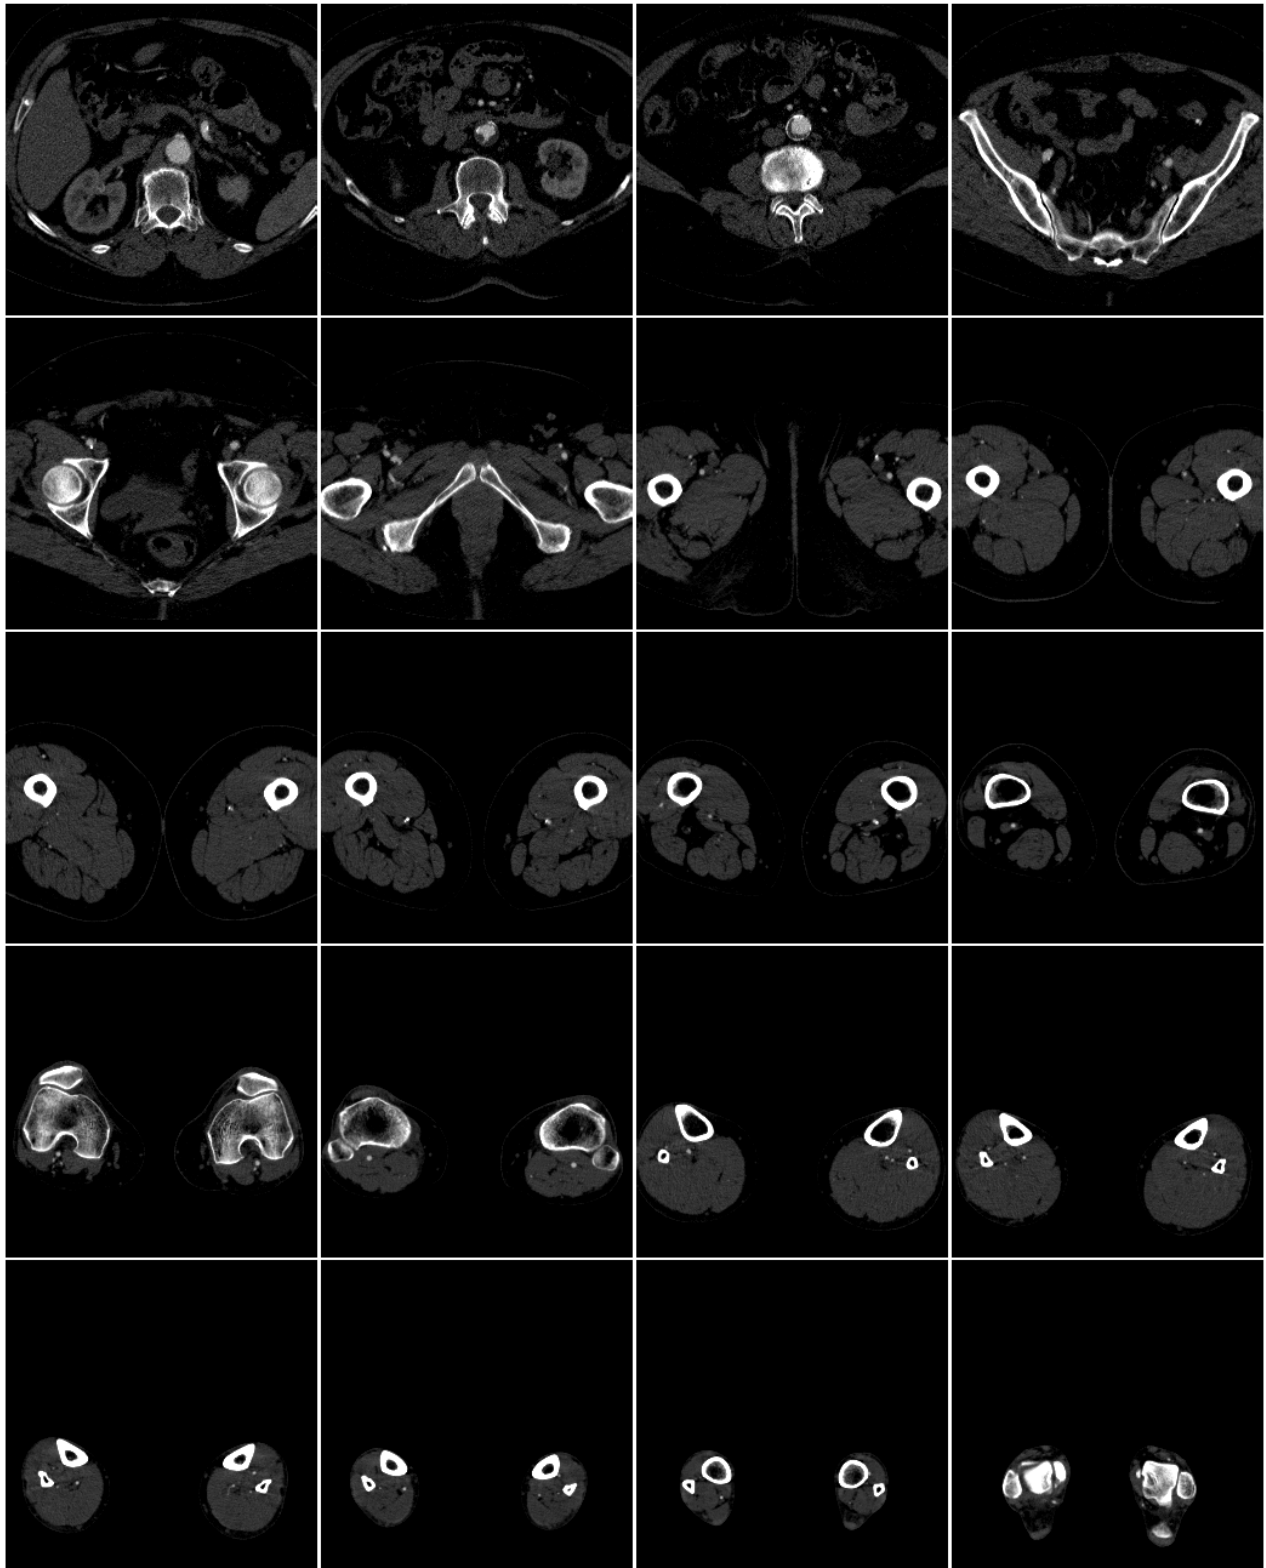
Sample slices from lower-extremities peripheral CT-Angiography dataset (top left to bottom right: from abdomen, through pelvis, thighs, knees, calves to ankle area). The images show axial view of the patients' body. Vessels are visible as smaller bright circular objects due to the contrast-medium enhancement of blood. The largest and brightest structures are bone tissue.
